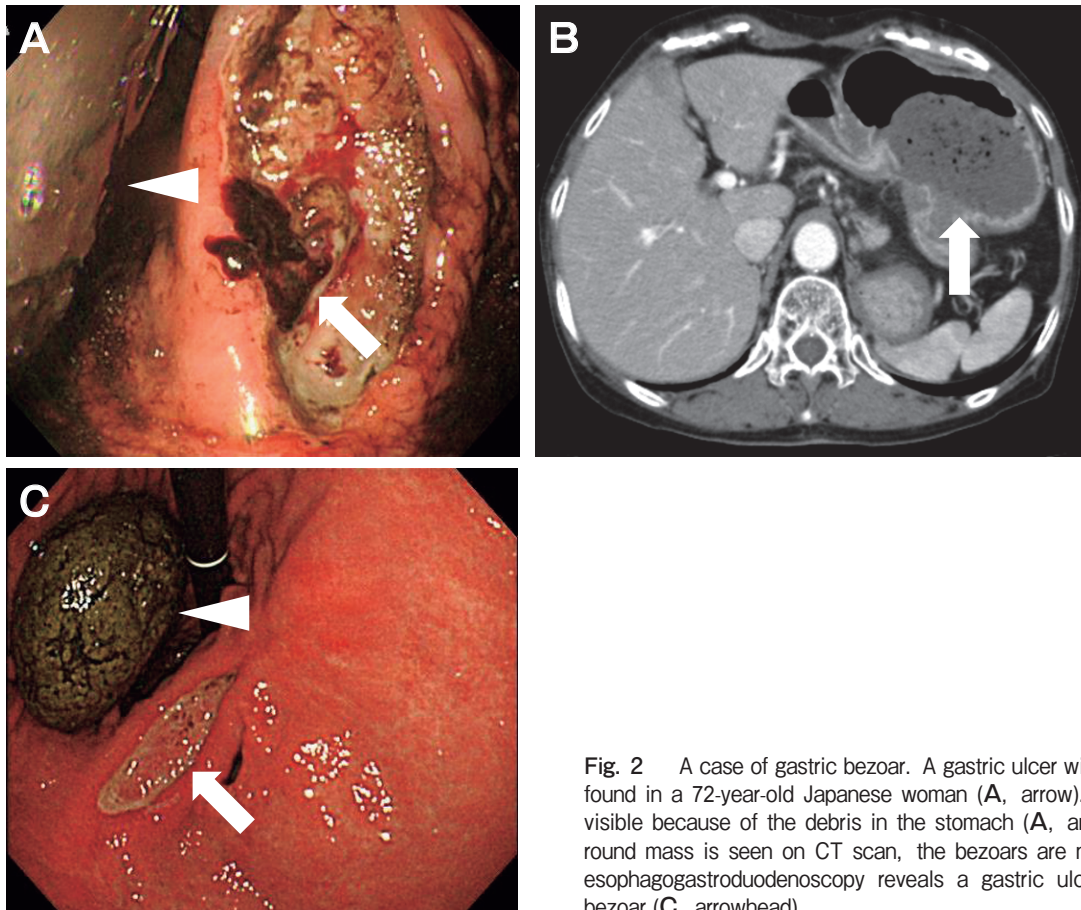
A case of gastric bezoar. A gastric ulcer with active bleeding was found in a 72-year-old Japanese woman (A, arrow). The bezoars are not visible because of the debris in the stomach (A, arrowhead). Although a round mass is seen on CT scan, the bezoars are not noted (B). Repeat esophagogastroduodenoscopy reveals a gastric ulcer (C, arrow) and a bezoar (C, arrowhead).
